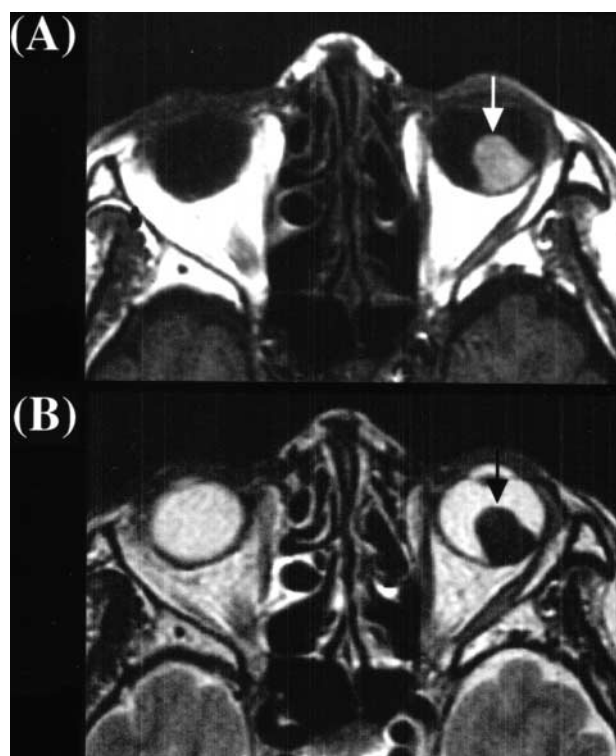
(A) Axial T1- and (B) T2-weighted MR images showing the tumor (arrow) attached to the posterior wall of the left eyeball. Note high signal intensity on the T1-weighted image and low signal intensity on the T2-weighted image.
